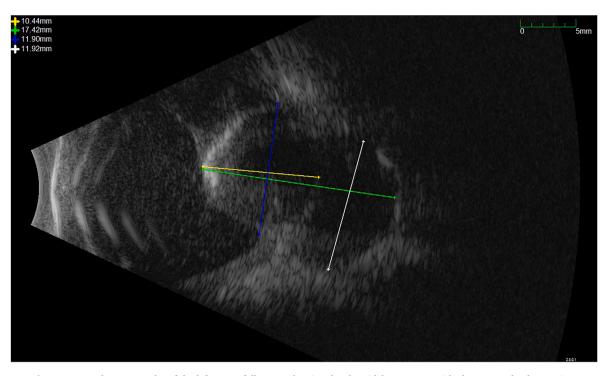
B-scan ultrasonography of the left eye at follow up, showing the choroidal mass, now with clear extrascleral extension.
